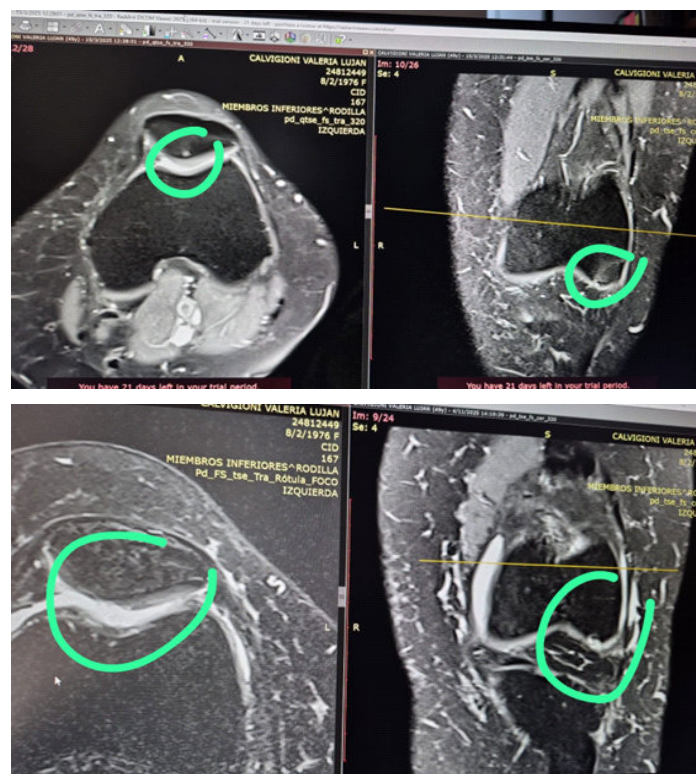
comparison in magnetic resonance imaging of lesions at baseline and at one year.
